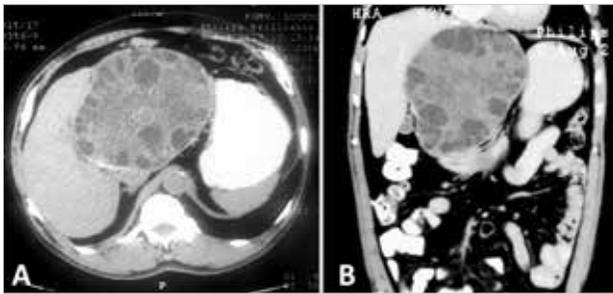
Computed tomography scan of the abdomen showing a large hepatic hydatid cyst in close relation to the hilum
